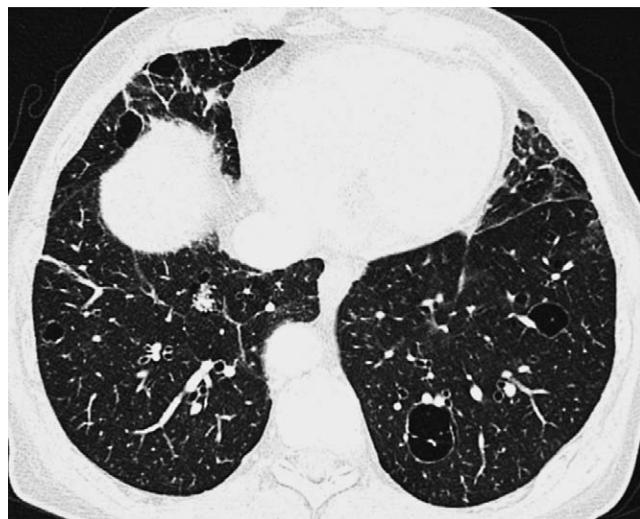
Chest CT in a patient with Sjögren's syndrome revealing cysts consistent with lymphocyte interstitial pneumonitis
